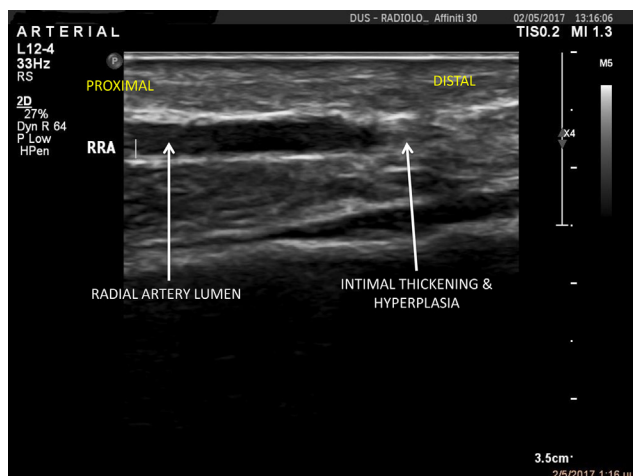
Radial artery ultrasound 1 week after its catheterization.
